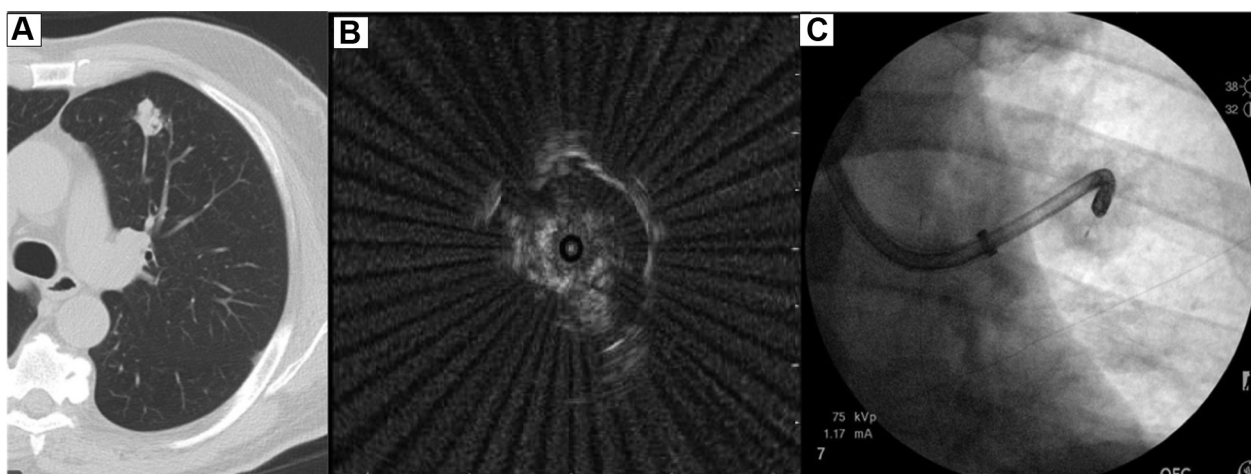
A-C: A, CT image; B, concentric radial endobronchial ultrasound view; C, robotic bronchoscopy with transbronchial needle aspiration.
